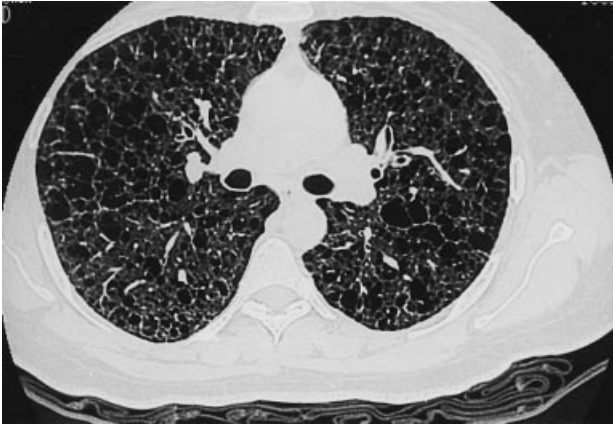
High resolution CT scan of the thorax showing multiple thin-walled cysts.
